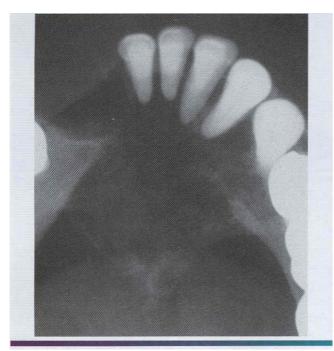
• Angiosarcoma. Occlusal radiograph showing a destructive, expansile tumor of the anterior mandible. (Courtesy of Dr. We. John.)
